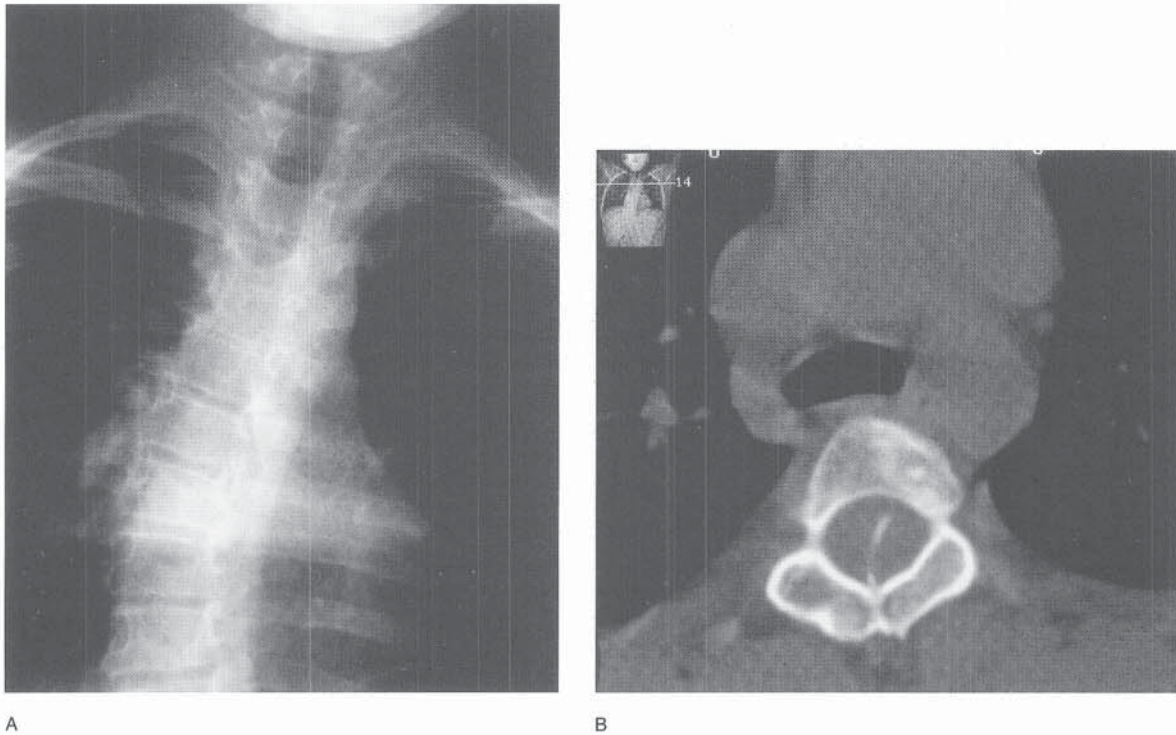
Imaging findings in a patient with an abnormal neurologic examination. A, A coned radiograph of the thoracic spine shows mild dextroscoliosis. B, A CT scan that was obtained after an MRI study reveals a diastematomyelia and a midline bony spur in the spinal canal.
